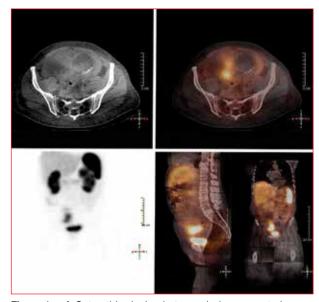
a-d: Octreotide single-photon emission computed tomography. Figure 1 a: Computed tomogaphy image showing mixed cystic and mixed solid pelvic mass. Figure 1 b: Still in coronal plane from a spinning maximum intensity projection isotope image: normal kidneys, bladder and spleen are seen with low level liver uptake. Uptake that is superior to the bladder is within the pelvis mass. Figure 1 c and d: Sagittal and coronal views of fused single-photon emission computed tomography data, all showing the increased isotope uptake centrally in the solid elements of the tumour on the overlying computed tomography images.
